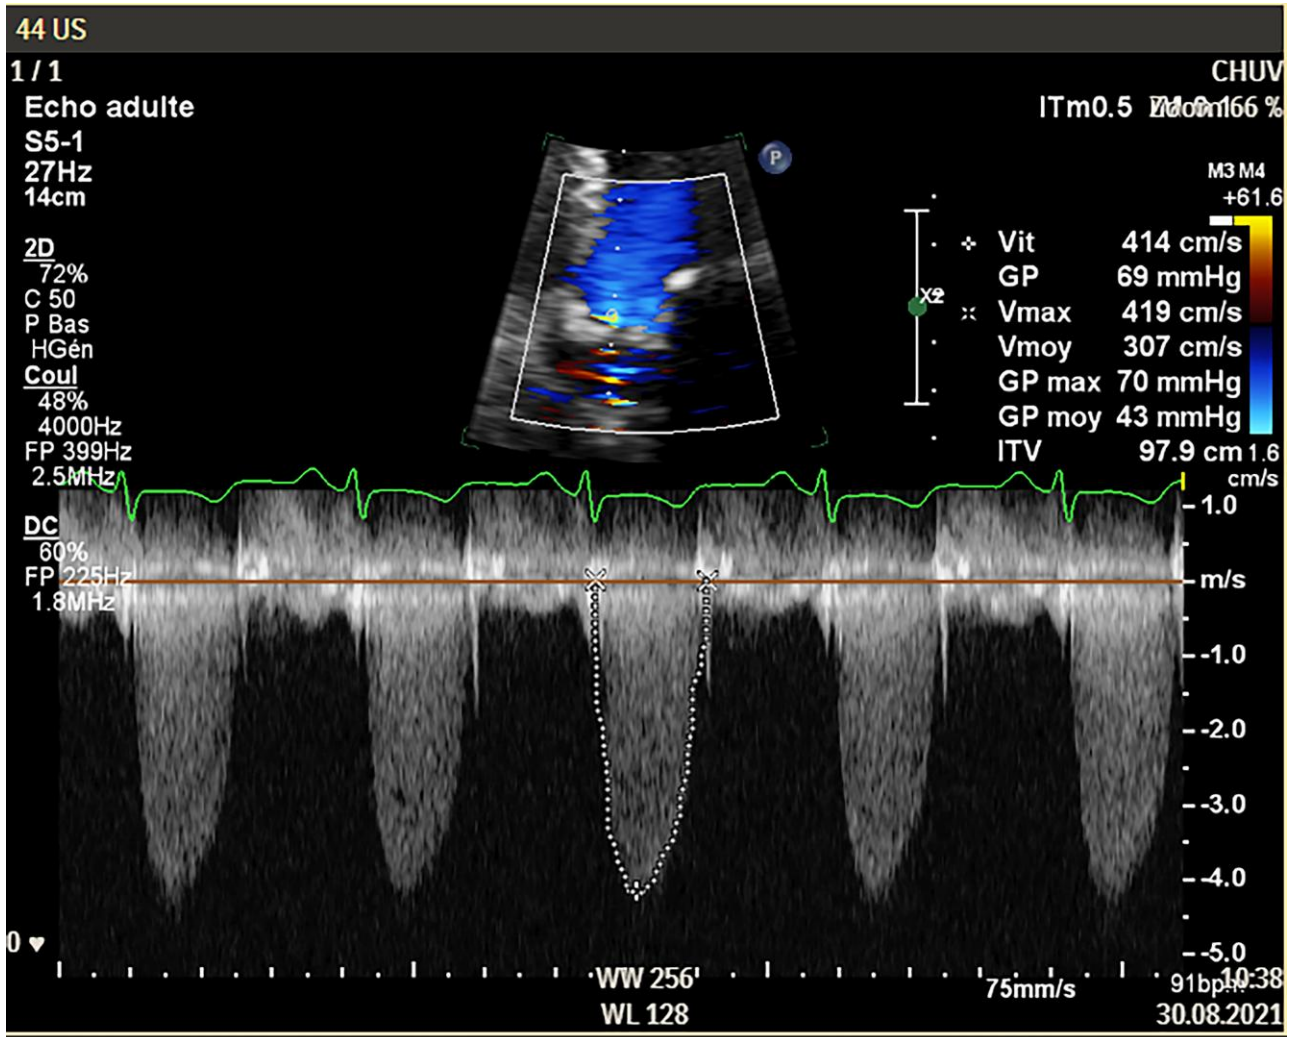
The transthoracic echocardiography confirmed a severe normal flow/high-gradient aortic stenosis with a mean gradient of 43 mmHg.
